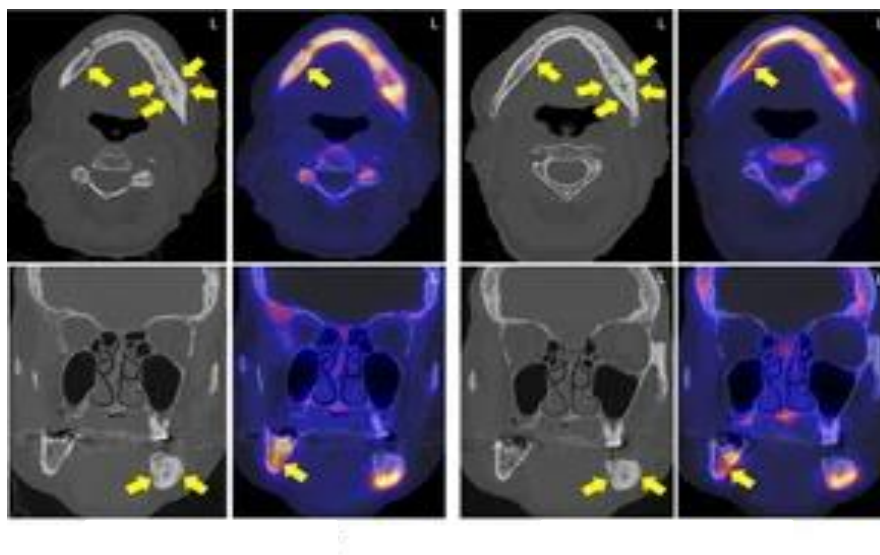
PET/CT image of the Medication-related osteonecrosis of the jaw
